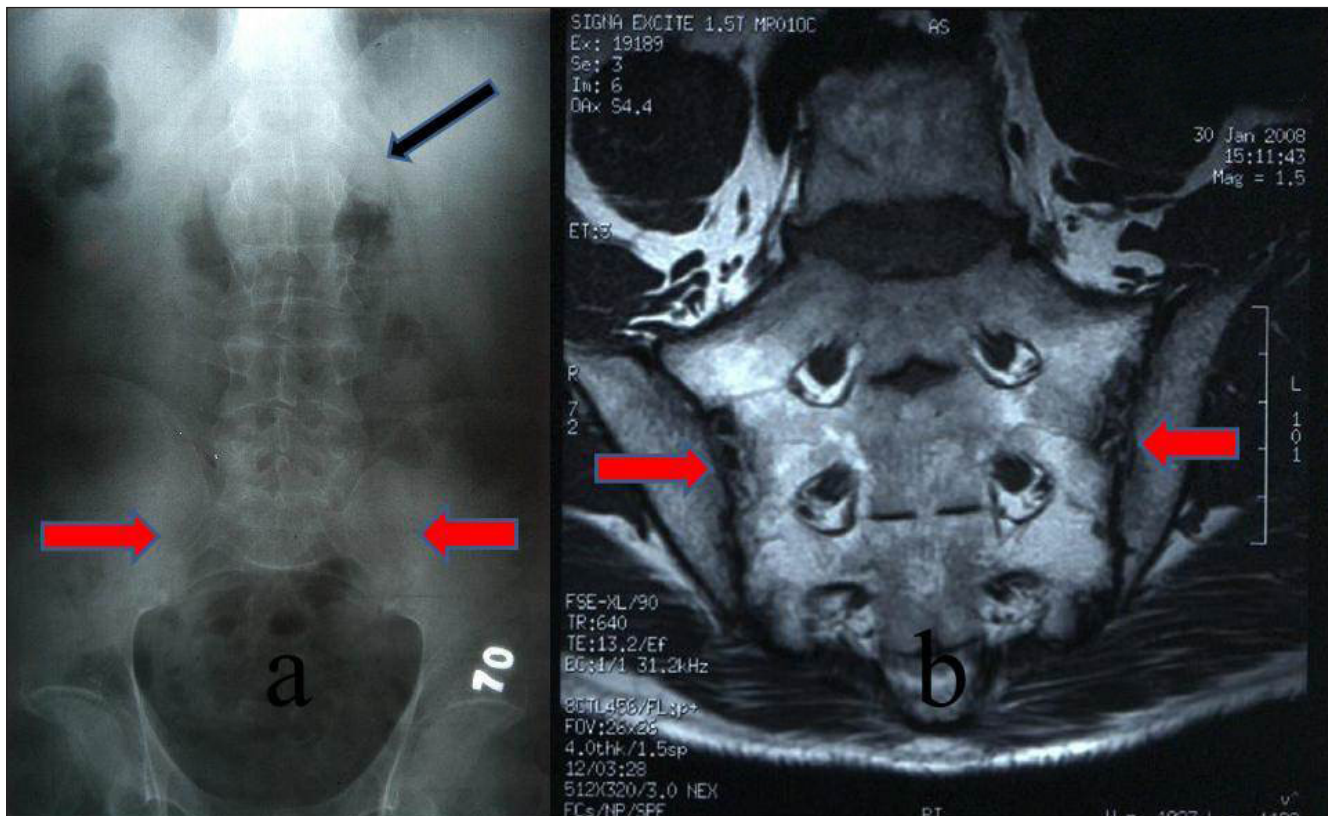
a: Anteroposterior plain radiograph of the pelvis revealed stage 3 bilateral sacroiliitis including irregular contour and erosions of the bones comprising both sacroiliac joints (red arrows), narrowing of the left sacroiliac joint space and syndesmophyte (black arrow) in the thoracolumbar part of spine.
